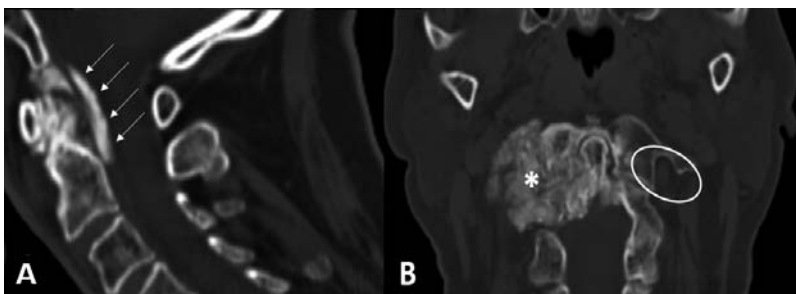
CT axial and MPR of cervical spine. CT shows a bulky laterocervical mass (asterisk) with calcium-like density without bone erosions that occupies almost totally the C2-C3 conjugation foramen and the lateral recess. MPR-reconstructed (A) sagittal scan visualizes the massive calcification of the transverse ligament (white arrows); and (B) coronal scan depicts the involvement of C2-C3 intertransversarii right foramen and a probable obstruction of vessels in it, while the left is clear and vertebral artery is patent (white oval). CT: computed tomography; MPR: multiplanar reconstruction scan.
